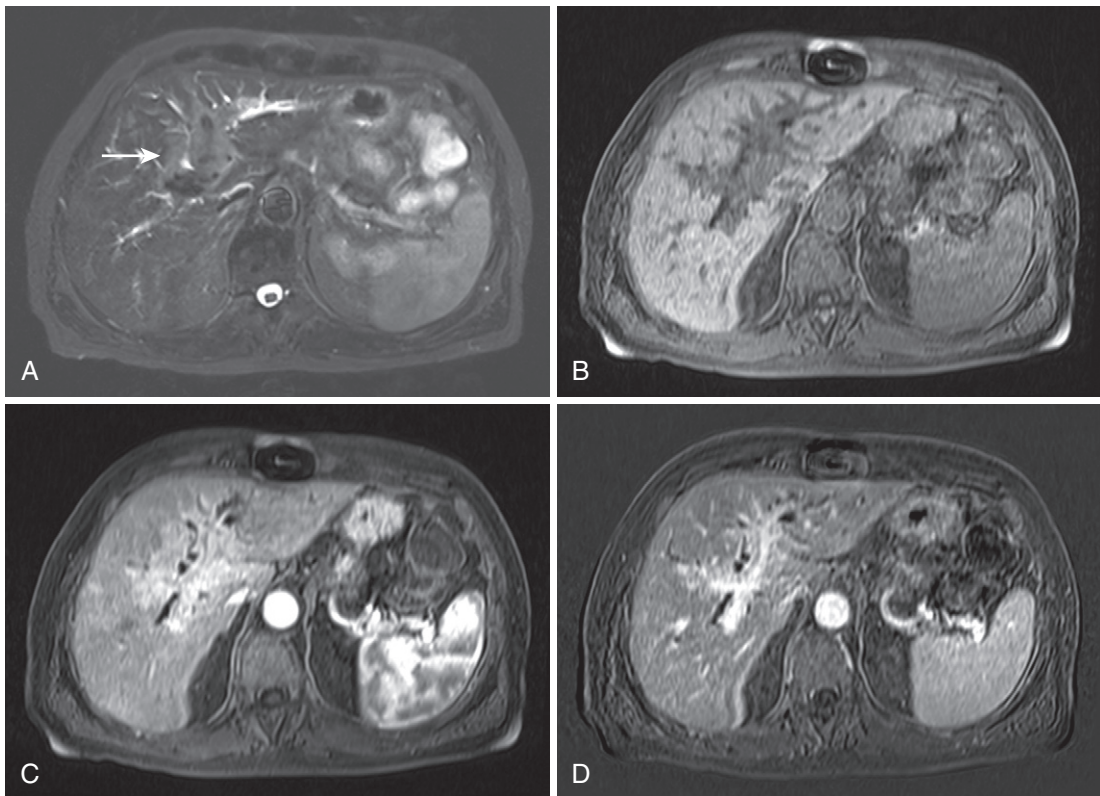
Hepatic lymphoma. A, Axial moderately T2-weighted image shows uniformly hyperintense material extending along the central portal tracts (*arrow*). Precontrast (B) and postcontrast (C) images depict associated enhancement, which is more conspicuous with the advantage of subtraction (D).
